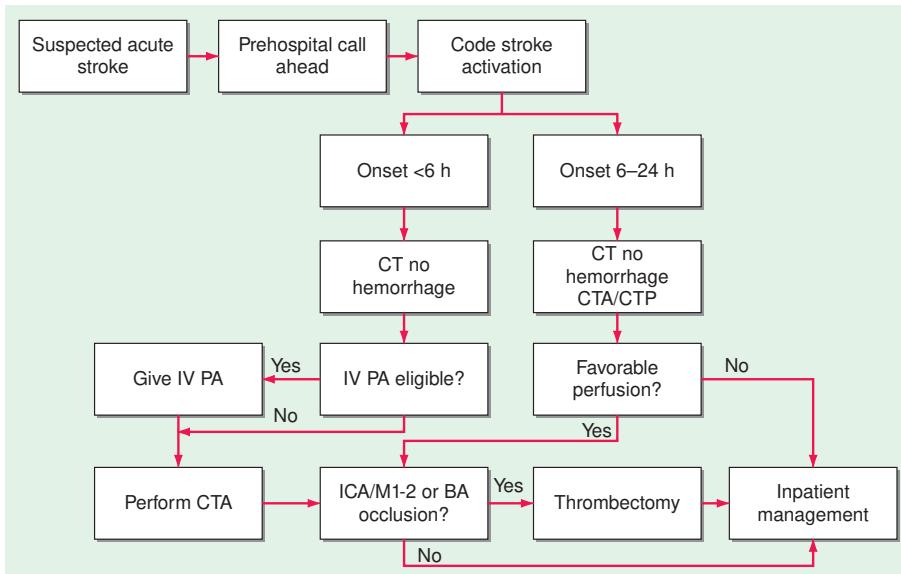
Management of acute stroke (pathway followed by the authors). For suspected stroke identified by prehospital professionals, we encourage calling ahead to the destination hospital. This allows early “stroke code” activation to prepare for an emergent computed tomography (CT) on arrival. For patients with onset <6 h from last time seen normal, we expedite a noncontrast head CT scan, and if free of hemorrhage and the patient is IV plasminogen activator (PA) eligible, this is administered in the CT scanner. (For IV tissue PA [tPA], the bolus is given and infusion initiated; for tenecteplase, the full dose is given as a bolus.) Then CT angiography (CTA) from left atrium to skull vertex is performed to identify an eligible target lesion for thrombectomy. For a patient presenting in the 6- to 24-h time window, PA is not considered, and the decision to perform thrombectomy is based on perfusion imaging.
